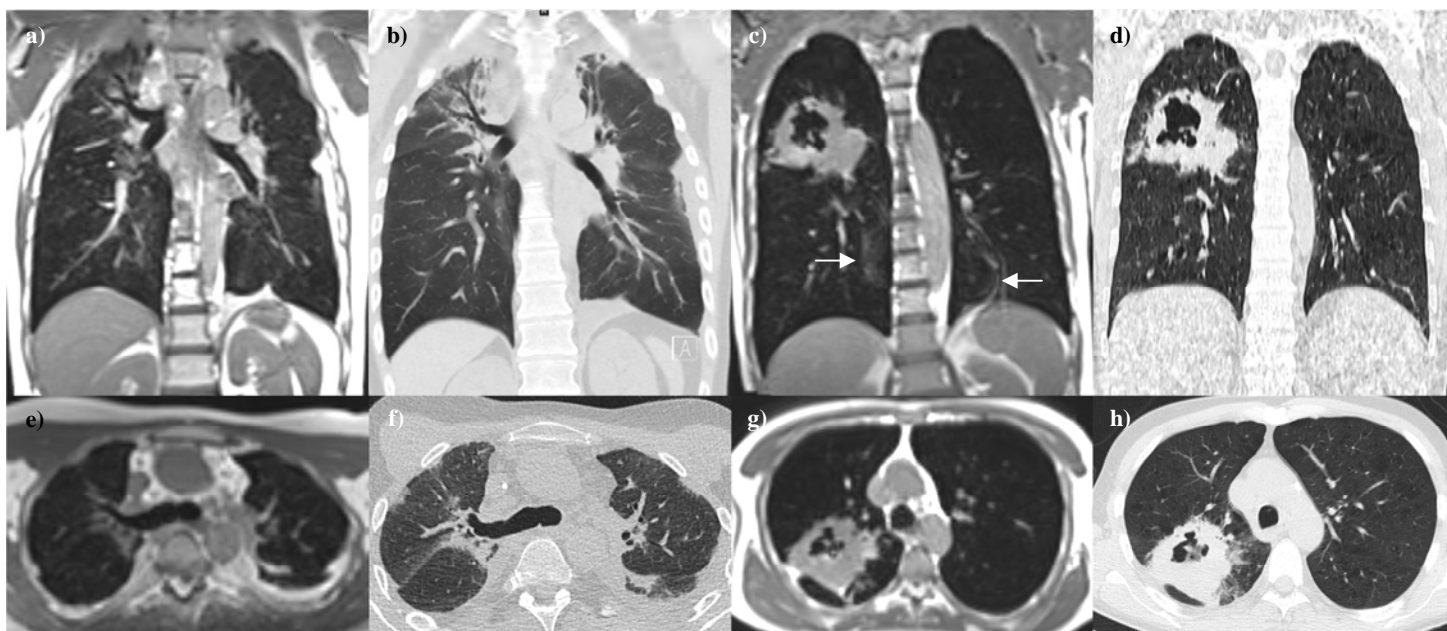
Sample images demonstrating coronal (a-d) and axial (e-h) reformats from 3D ufSSFP MRI (a, c, e, g) and CT (b, d, f, h) obtained in a 28 y old male with chronic pulmonary GvHD and BO (FEV1=14% of normal) (a, b, e, f) and in a 54 y old male with centrally necrotic lung cancer from the left upper lobe (FEV1=45% of normal) (c, d, g, h). Note the absence of banding and breathing motion artifacts in the ufSSFP images. Artifacts from cardiac pulsation, however, are still seen (arrows in c).
